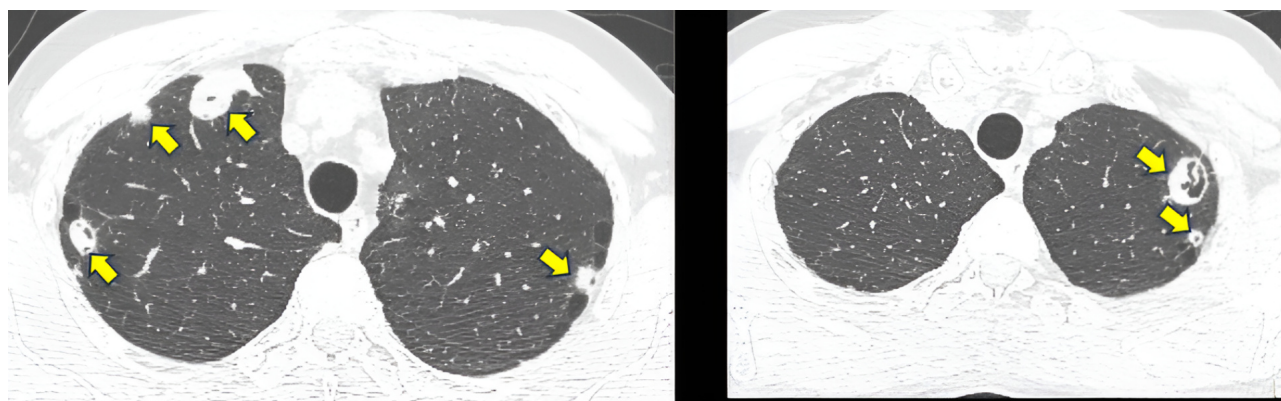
Chest CT scan of patient K. multiple heterogeneous foci are detected in both lungs (indicated by yellow arrows), some of which have signs of cavitation. Computed tomography of the paranasal sinuses showed thickening of the mucous membrane in the left frontal sinus, a polyp in the right nasal cavity, and a deviated nasal septum. Axonal sensory polyneuropathy of the lower extremities was detected on stimulation electroneuromyography. Ophthalmologist's examination: OD—anophthalmia, OS—necrotizing scleritis. Scleral staphyloma. Marginal vascularized corneal clouding, complicated by mature cataract. Total retinal detachment. Consultation with an otorhinolaryngologist: nasal cavity polyp on the right.
